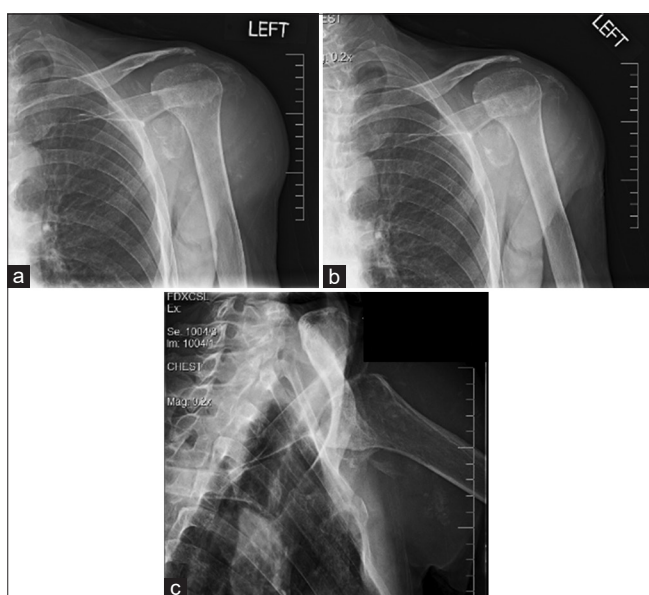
Plain radiographs left shoulder: (a) AP projection. (b) Rotation projection. (c) Transthoracic lateral
